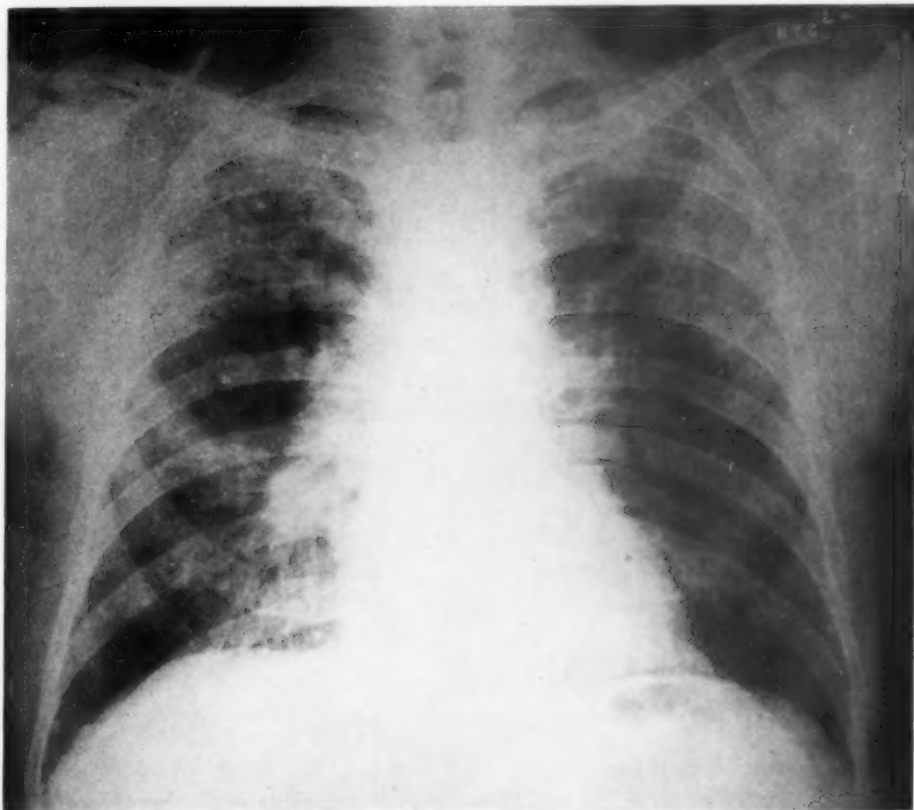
(Case 5.) Roentgenogram taken September 15, 1939. Right lung relatively unchanged. Reappearance of dense infiltration in the left upper lobe.
